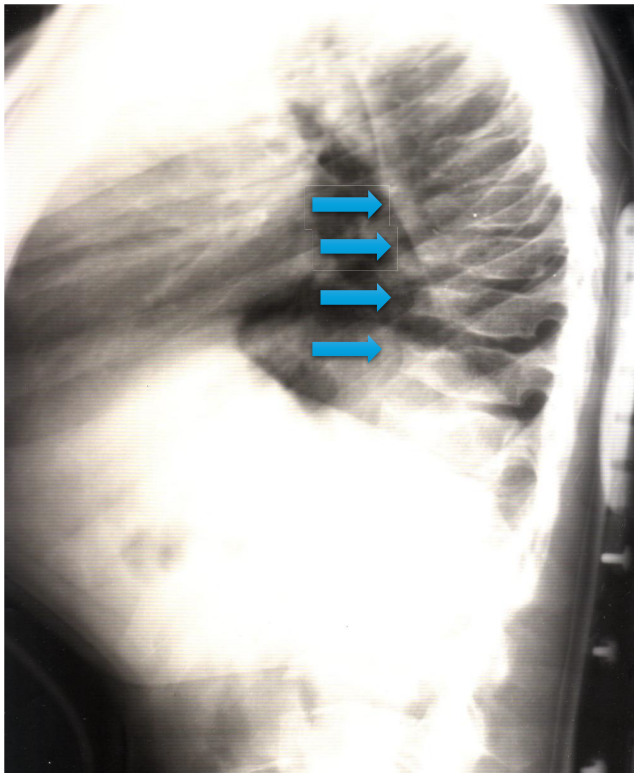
Lateral projection x-ray of the spine. Arrows highlight flattened vertebral bodies in the spine (platyspondyly) with typical bullet-shaped changes in several vertebrae.
